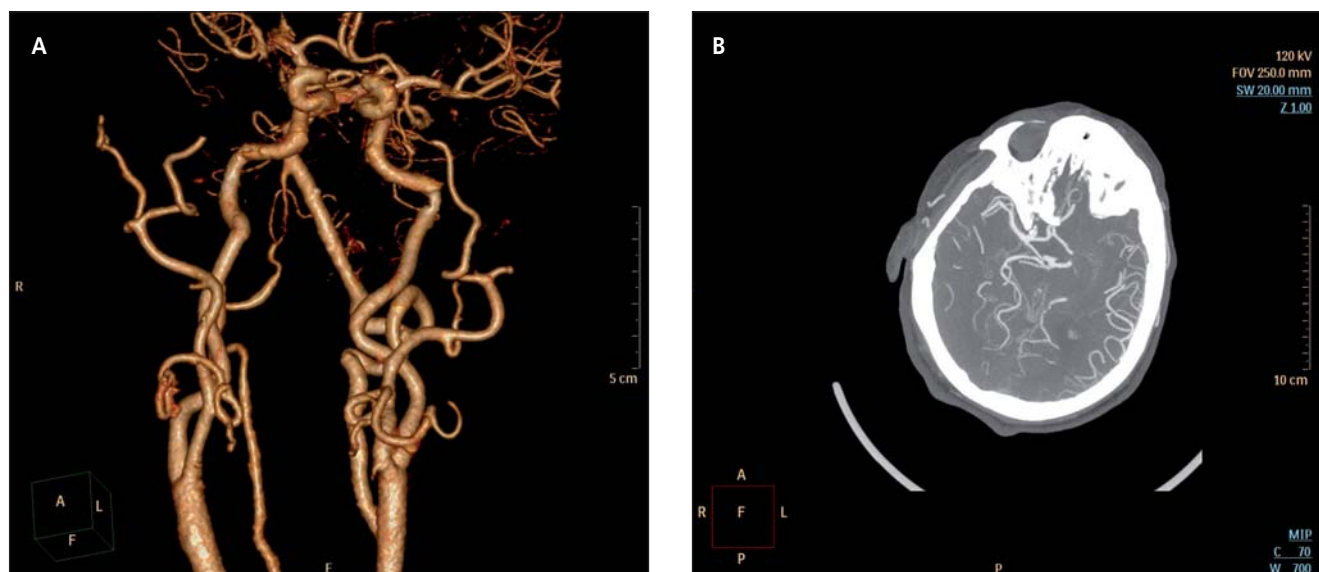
(A) Postprocedure CT angiography (reconstruction). (B) Postprocedure CT angiography.
